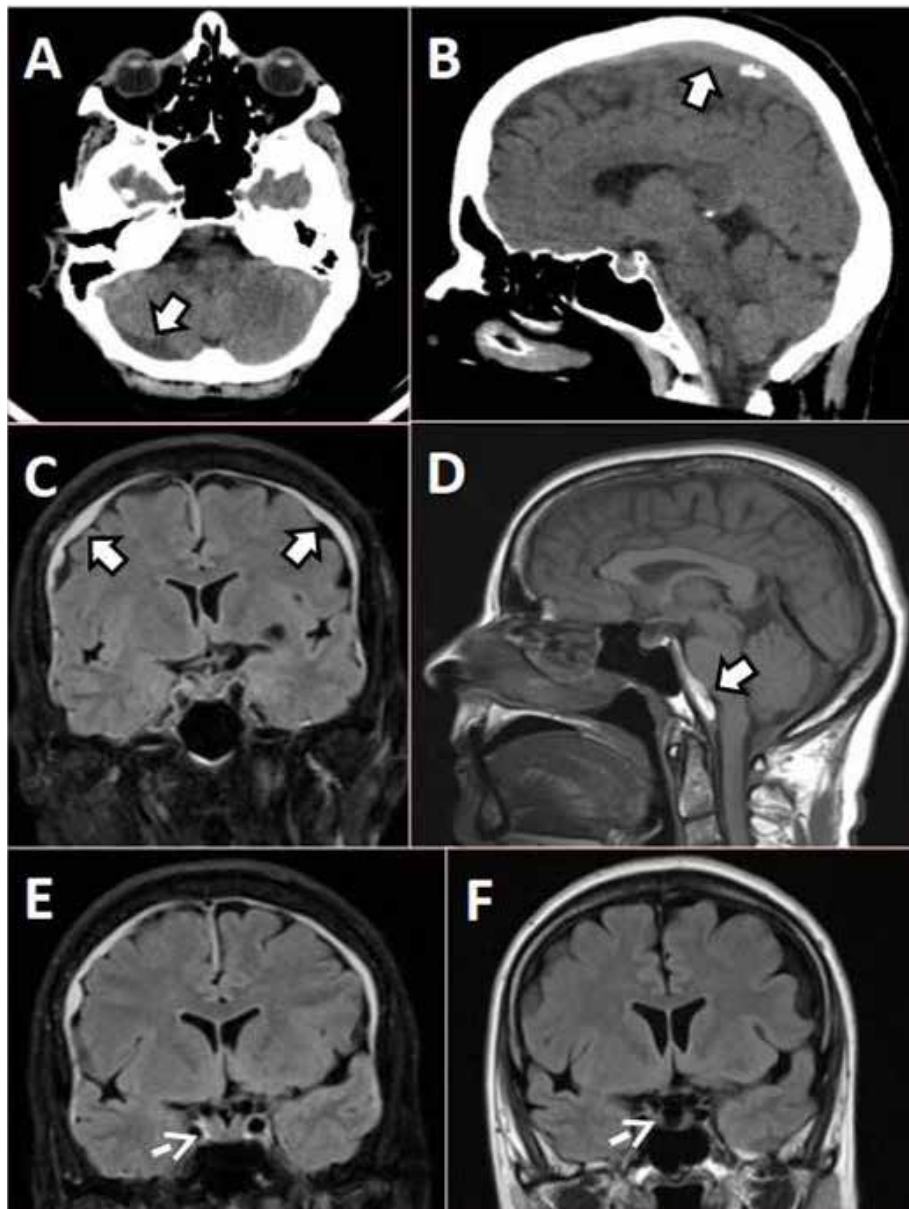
A, B) CT scan at admission shows thickening of the transversal left sinus and the sagittal sinus (arrows). C) MRI FLAIR coronal image shows diffuse bilateral meningeal thickening (arrow). D) MRI T1 sagittal image shows hyperintense subdural hematoma at the clivus (arrow). MRI FLAIR coronal reconstructions show enlargement of the pituitary gland during the acute phase (E) in comparison with previous examination available (F).
